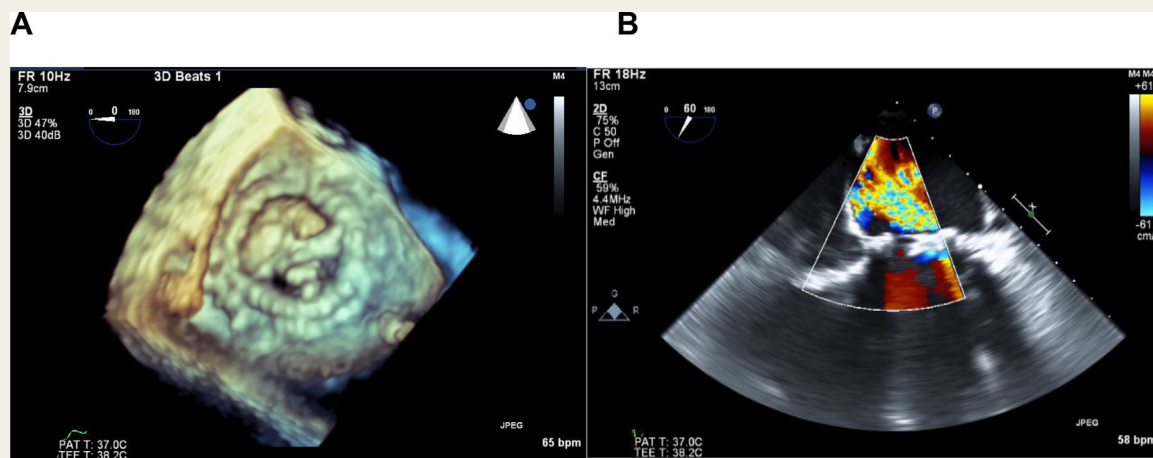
Transoesophageal echocardiography demonstrating the degenerative mitral bioprosthesis on 3D imaging (A) and severe mitral regurgitation (B).
